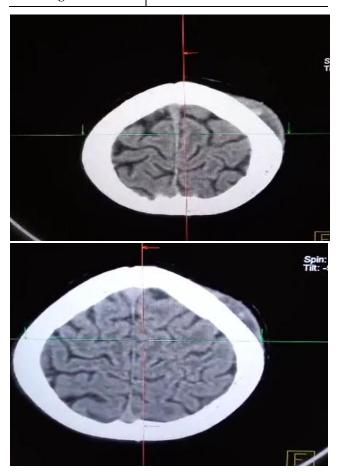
Head CT-Scan showing subgaleal fluid collection
